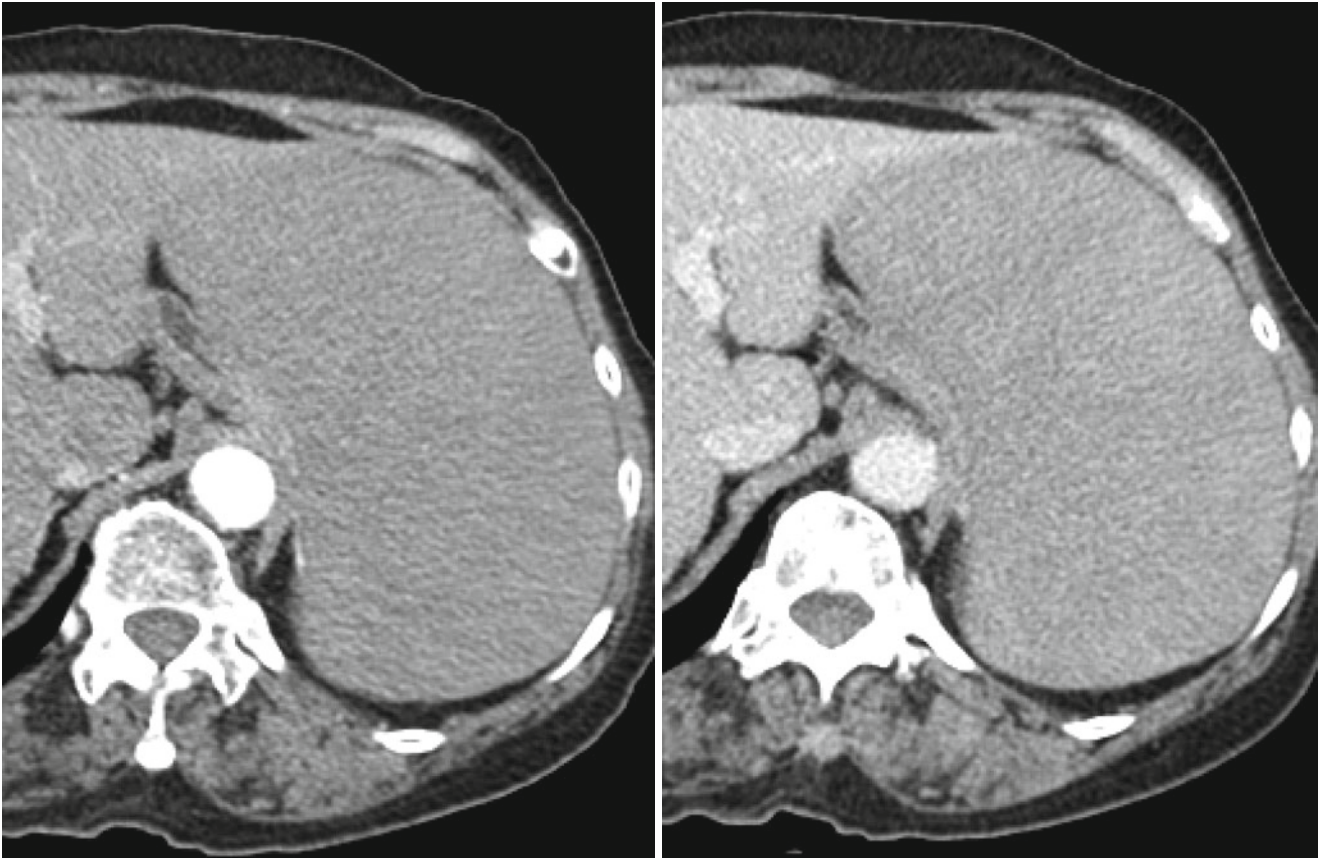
A 72-year-old female with diffuse large B-cell lymphoma. Splenomegaly with diffuse low attenuation is noted both on arterial (*left*) and portal (*right*) phase CT images. There is no discernible focal lesion in the spleen
